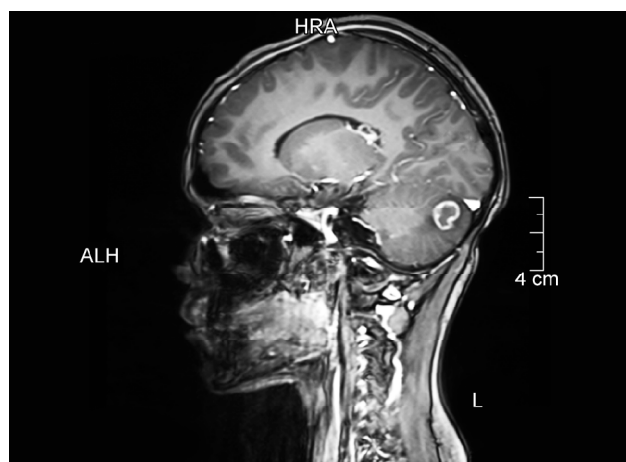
Contrast-enhanced MRI brain T1W sagittal image showing irregular ring enhancing lesion in the posterior cerebellum
